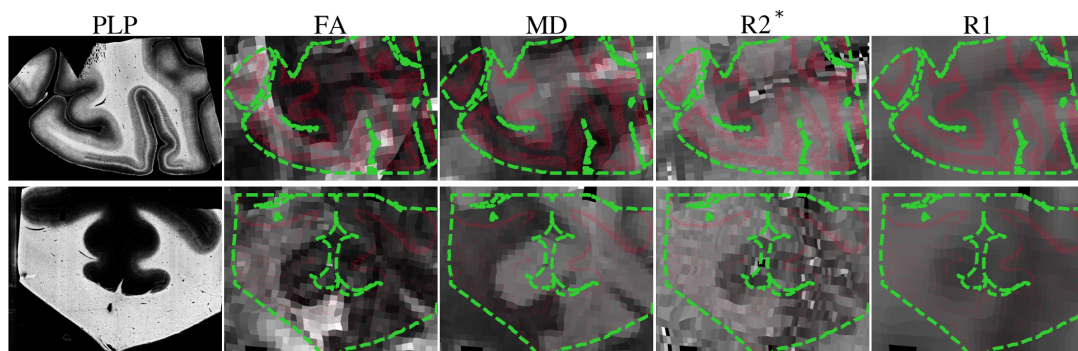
Examples of bad MRI-IHC co-registrations that were excluded from the analysis. This figure is interpreted similarly to Figure 4.4. Contours of the tissue mask (green dashed) generated from the PLP slide were observed to be completely misaligned with the MRI-derived parameter maps.
